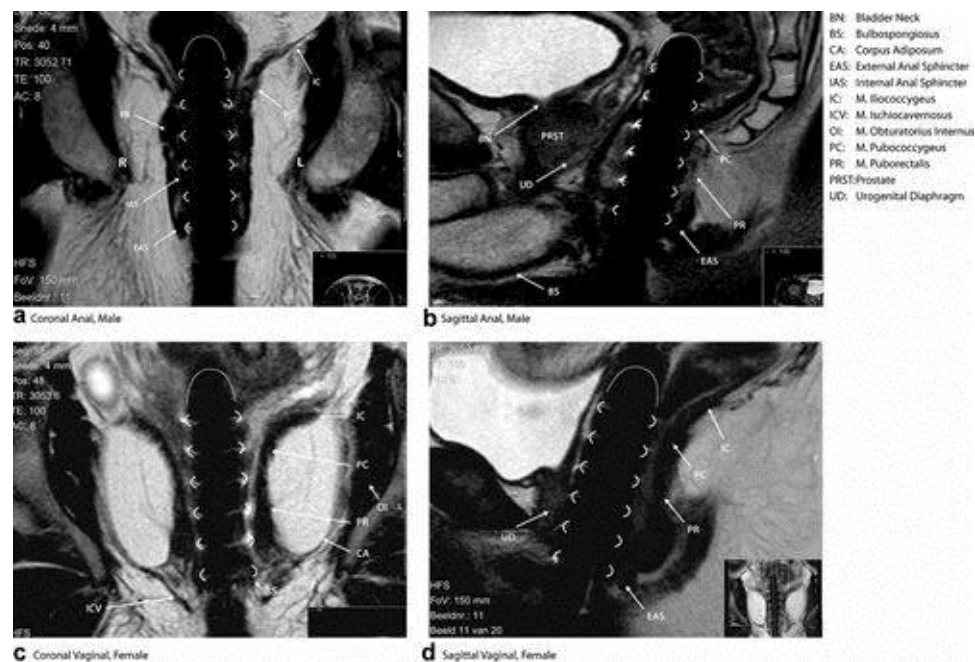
MRI of pelvis with anal probe in situ, confirming correct placement for sEMG detection.
